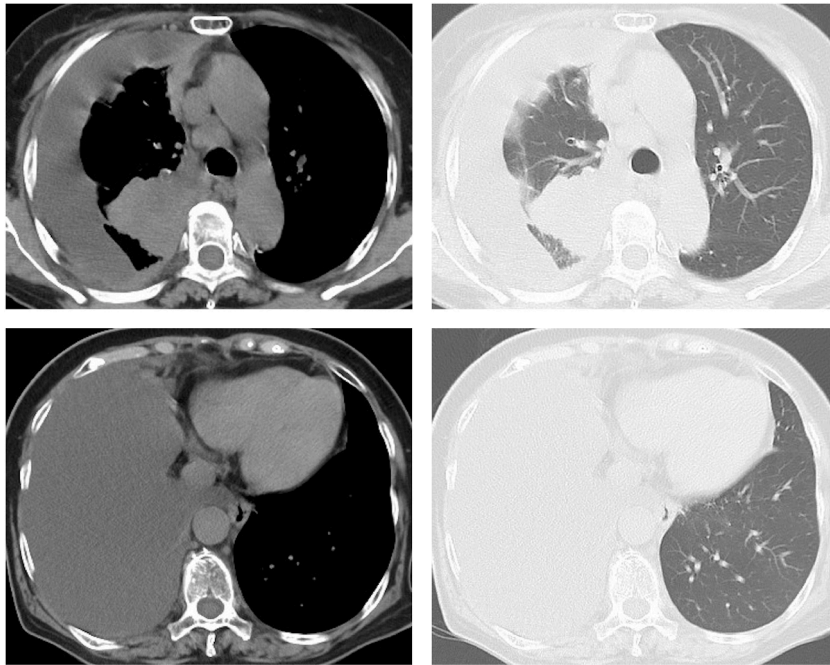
Chest computed tomography revealing right-sided pleural effusion and a mass in the right upper lung.
